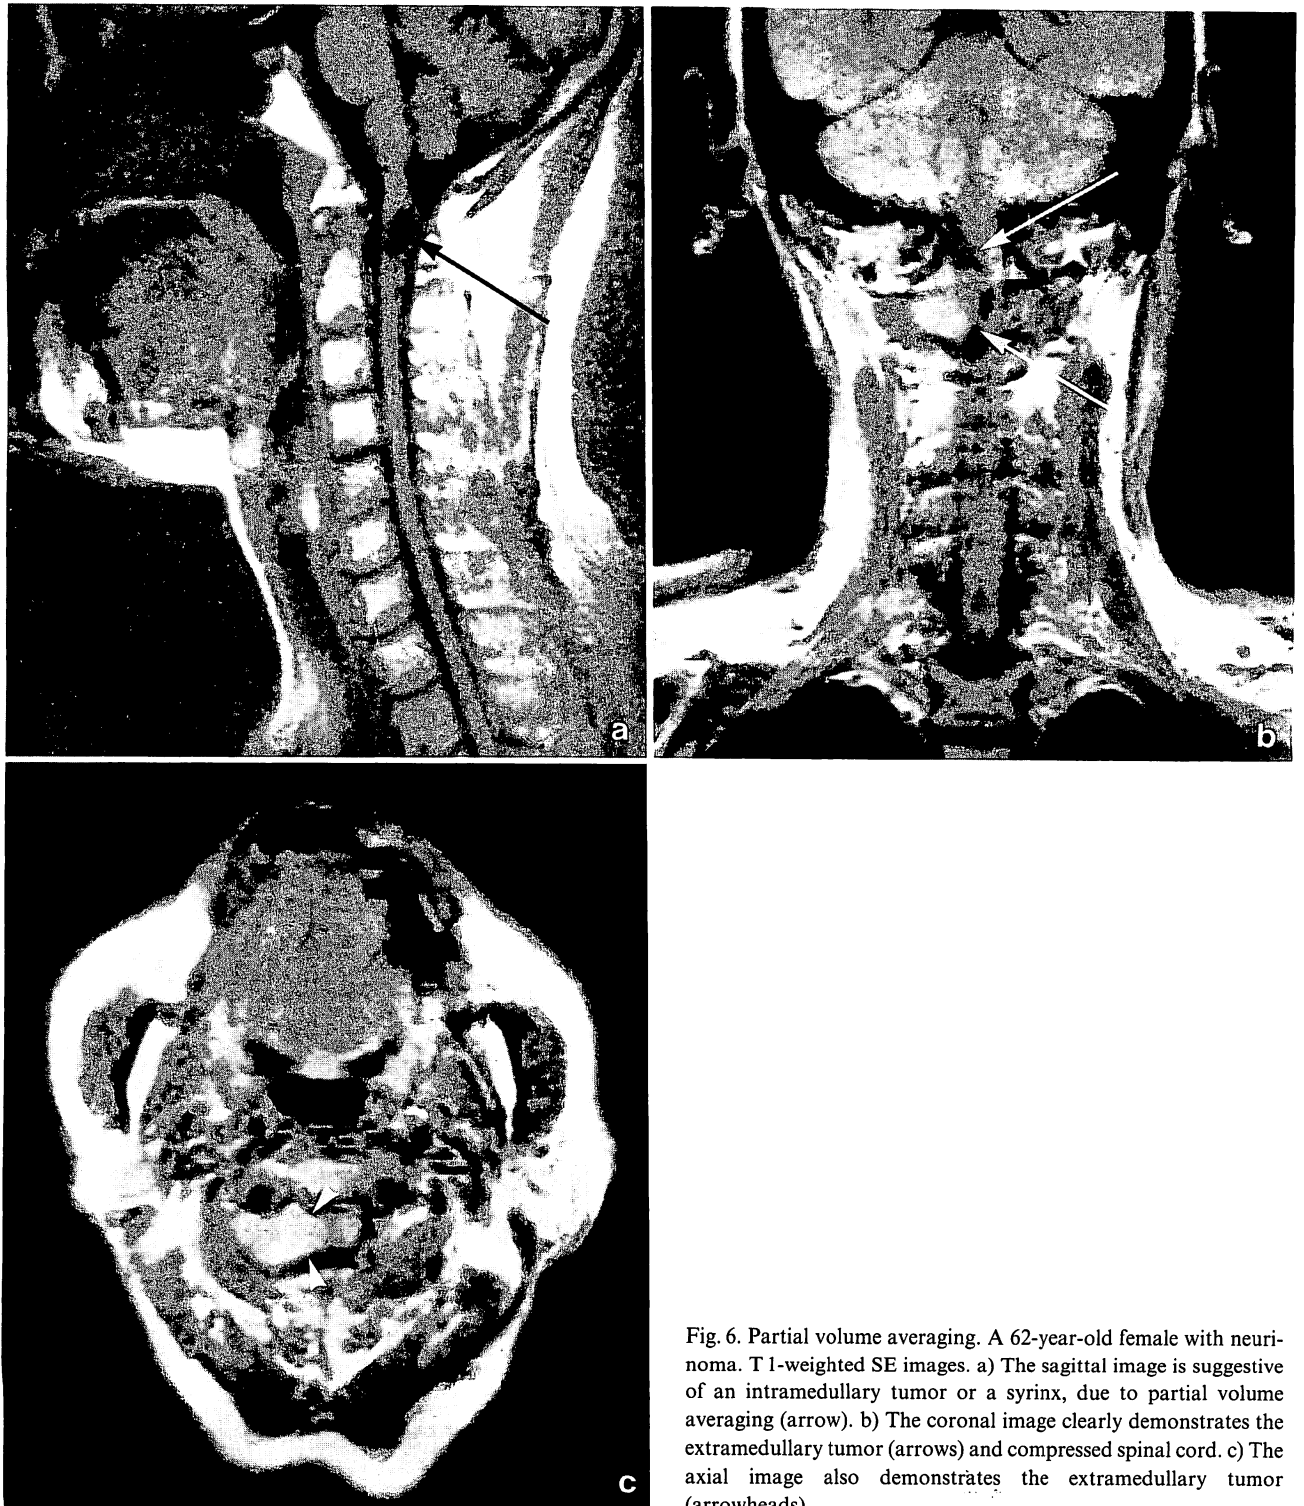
Partial volume averaging. A 62-year-old female with neuroinoma. T1-weighted SE images. a) The sagittal image is suggestive of an intramedullary tumor or a syrinx, due to partial volume averaging (arrow). b) The coronal image clearly demonstrates the extramedullary tumor (arrows) and compressed spinal cord. c) The axial image also demonstrates the extramedullary tumor (arrowheads)
